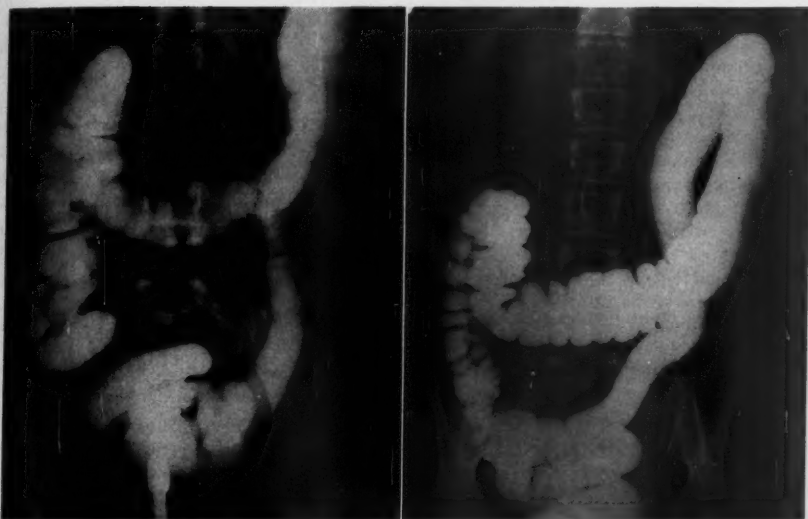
(case 2). *Left*, roentgenograph with barium in the sigmoid colon, outlining several redundant loops. *Right*, roentgenographic examination after removal of 35 cm. of sigmoid colon, visualizing distal bowel within normal limits.
